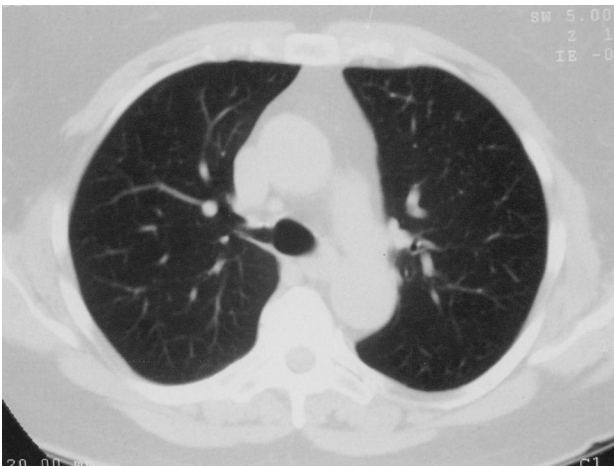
Computed tomogram of the chest. This slice is through the trachea, 2 cm above the main carina and shows the take-off of the tracheal bronchus into the apical segment of the right upper lobe.
